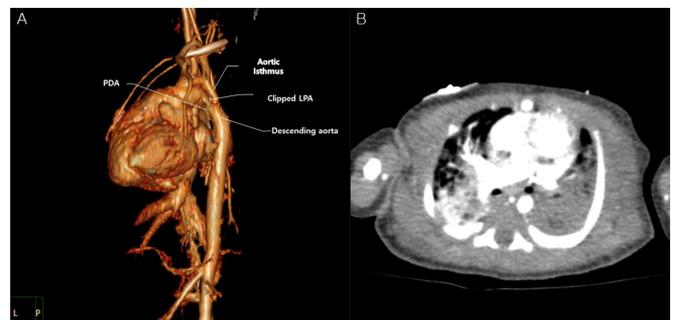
Chest CT angiography on postoperative day (POD) 2 following the initial operation. (A) Reconstructed 3D image showing the clipped LPA and remaining PDA. A narrow aortic isthmus was observed and PDA remained. The left pulmonary artery was clipped. (B) Chest CT showing interruption of left pulmonary artery blood flow. There was no left pulmonary artery blood flow due to inadvertent clipping.
